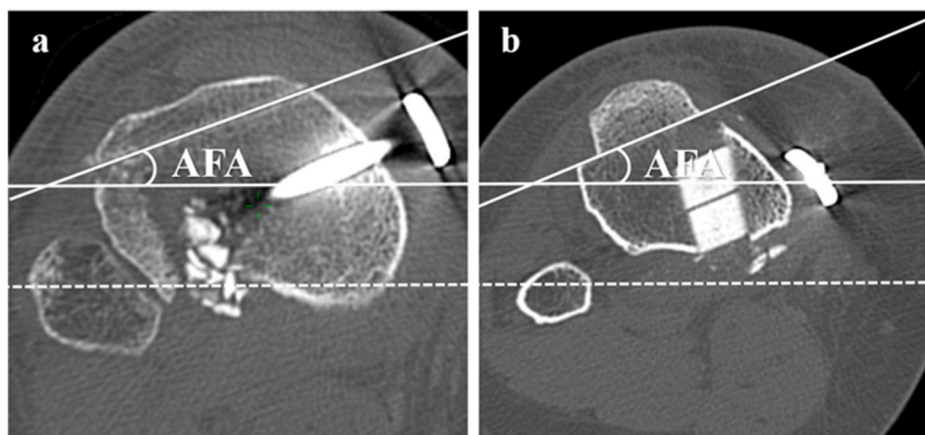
Measurement of axial flange angle (AFA) on axial CT slice in (a) high tibial osteotomy and (b) distal tuberosity osteotomy. AFA was measured as the angle between the posterior condyle axis of the proximal tibia (the dotted line) and the flange osteotomy surface.
